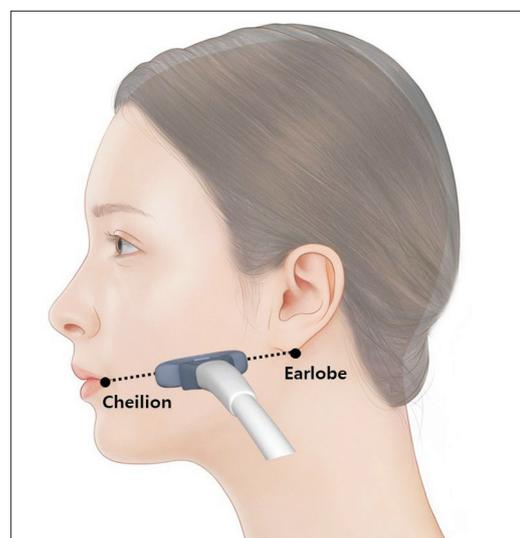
The placement of the probe of ultrasonography has been placed in the line connecting ear lobe and cheilion.
